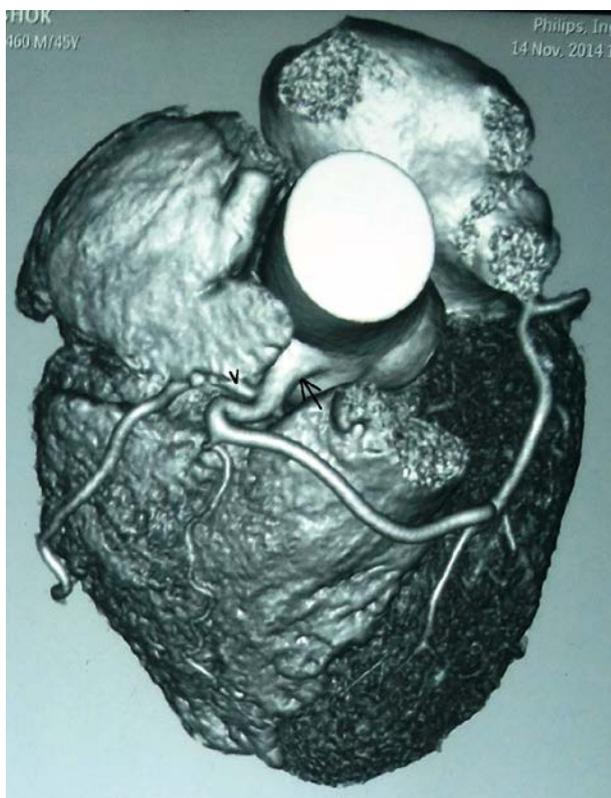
CT coronary angiography showing course of anomalous originating left coronary artery anterior(arrow) to pulmonary trunk
